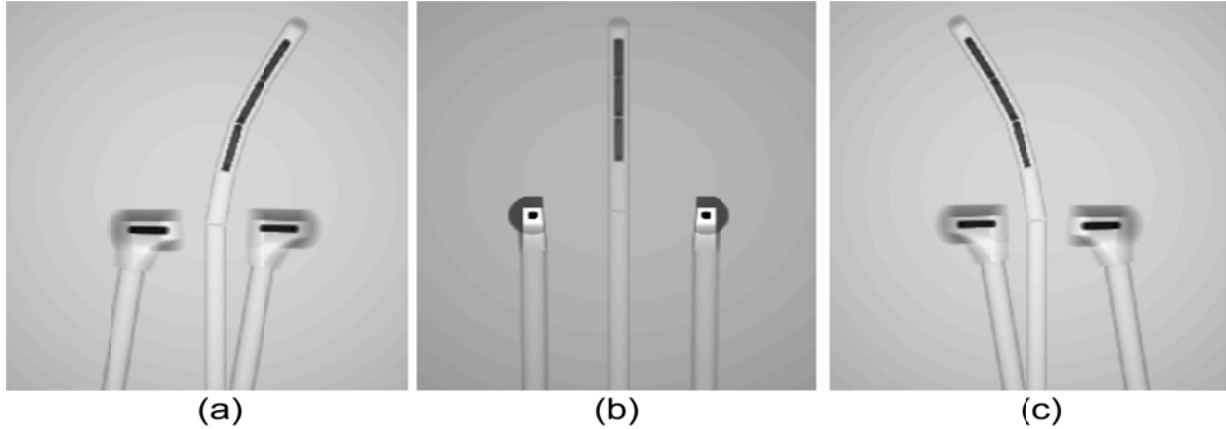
Computed CBCT projection images of the bilateral colpostats and central intrauterine tandem, reproducing clinical LDR treatment arrangement when using merge code.⁶⁰ Any angle projection around 360° gantry rotation can be acquired, for example, in this case, (a) projection with -30°, (b) projection with 0°, and (c) projection with +30° gantry angle, respectively.
